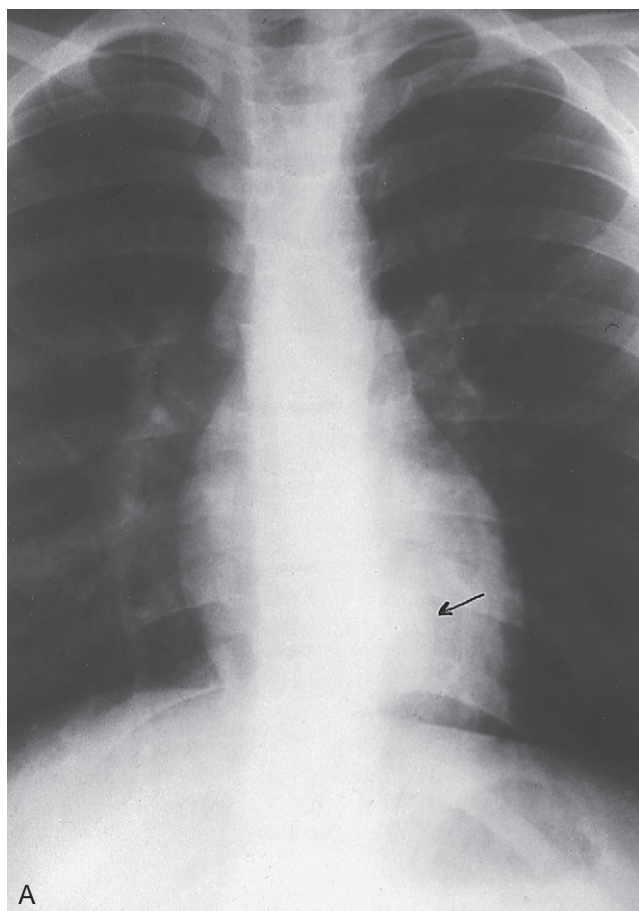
A, Incidental finding of an asymptomatic mediastinal mass behind the cardiac silhouette on anterior chest radiograph (arrow). B, On lateral film, the lesion was located just inferior and posterior to the base of the heart (arrow) and adjacent to the esophagus.
